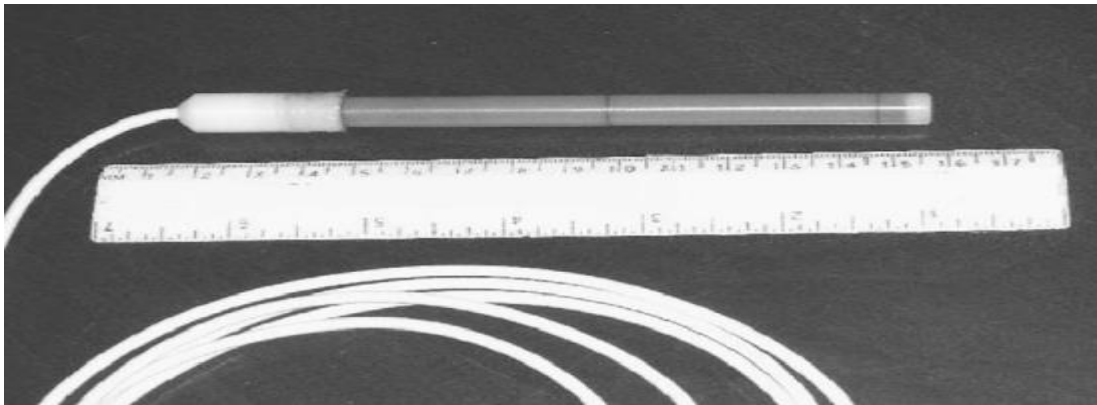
Example of 100-mm-long CT ionization chamber for measuring CTDI.
